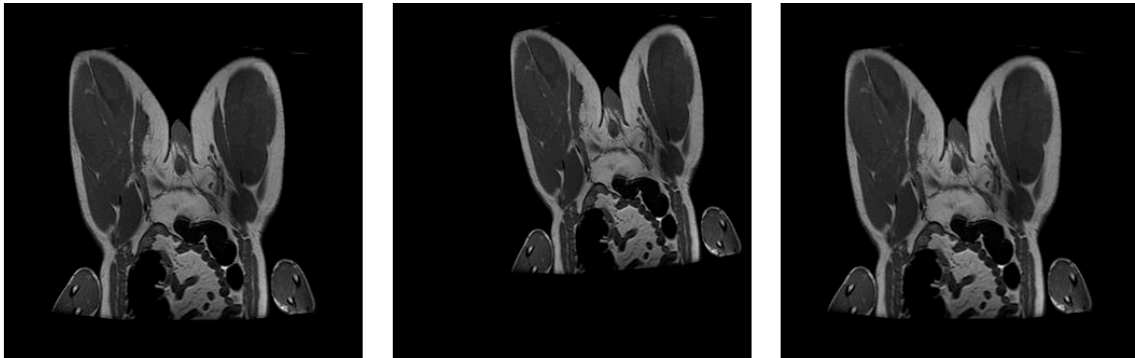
Rectification of T1-weighted MRI from PELVIS test set
